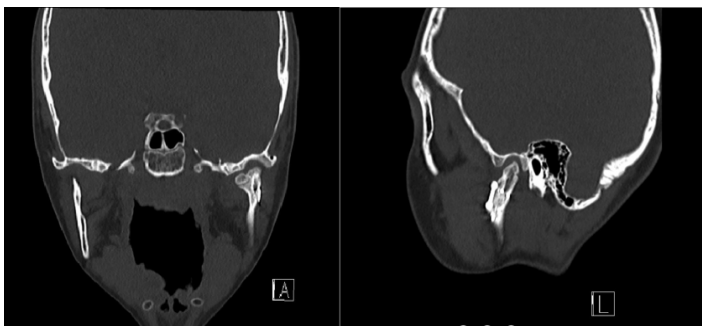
CT scan sample for a late term result of poor healing in the condyle after ORIF operation. Left: coronal view, Right: Sagittal view
